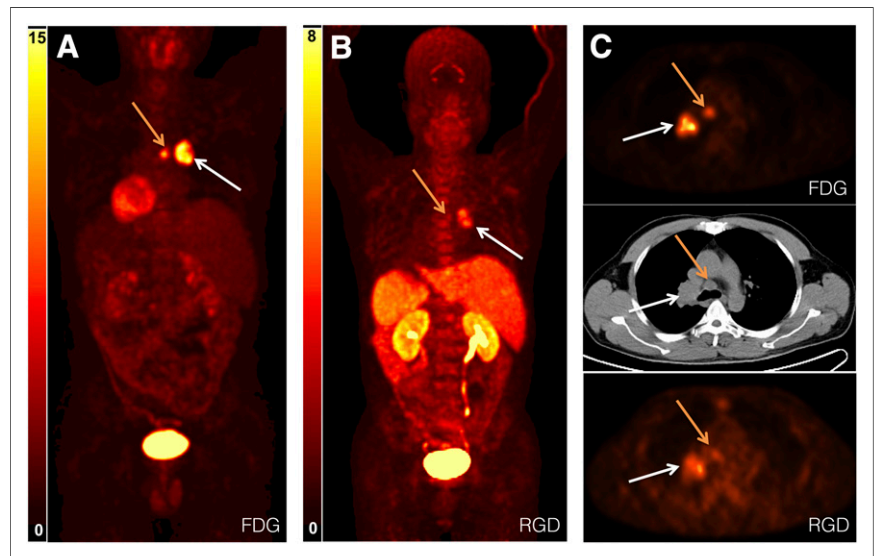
^{18}F -FDG (A) and ^{18}F -alfatide (B) maximum-intensity-projection imaging of patient (patient 8 in Table 1) with primary squamous carcinoma (white arrow) and lymph node metastasis (yellow arrow). (C) Transaxial PET image with administration of ^{18}F -FDG (upper) and ^{18}F -alfatide (lower) and corresponding CT image (middle) covering carcinoma and lymph node metastasis.
